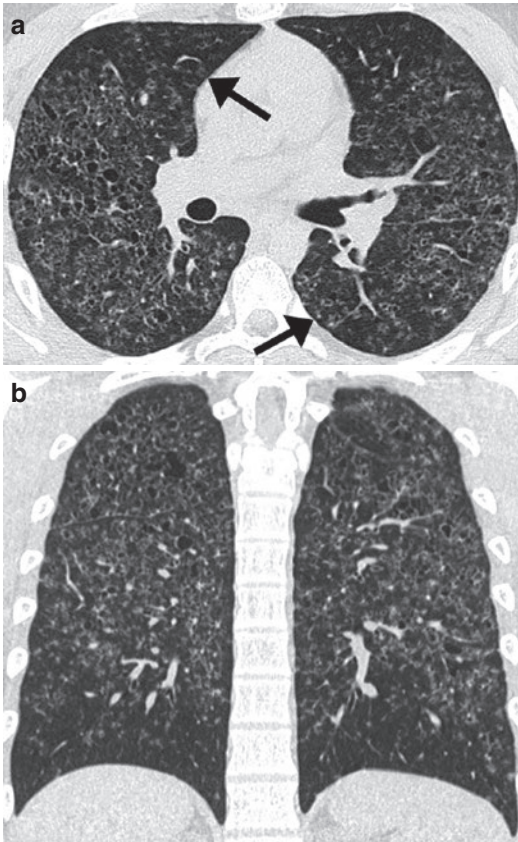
(a, b) Pulmonary Langerhans cell histiocytosis in a 26-year-old man. Axial CT image demonstrates bilateral, thin-walled cysts of variable size and multiple, ill-defined nodules (arrows) (a). Coronal CT image better demonstrates the upper and middle lung zone predominance with relative sparing of the lung bases (b)
